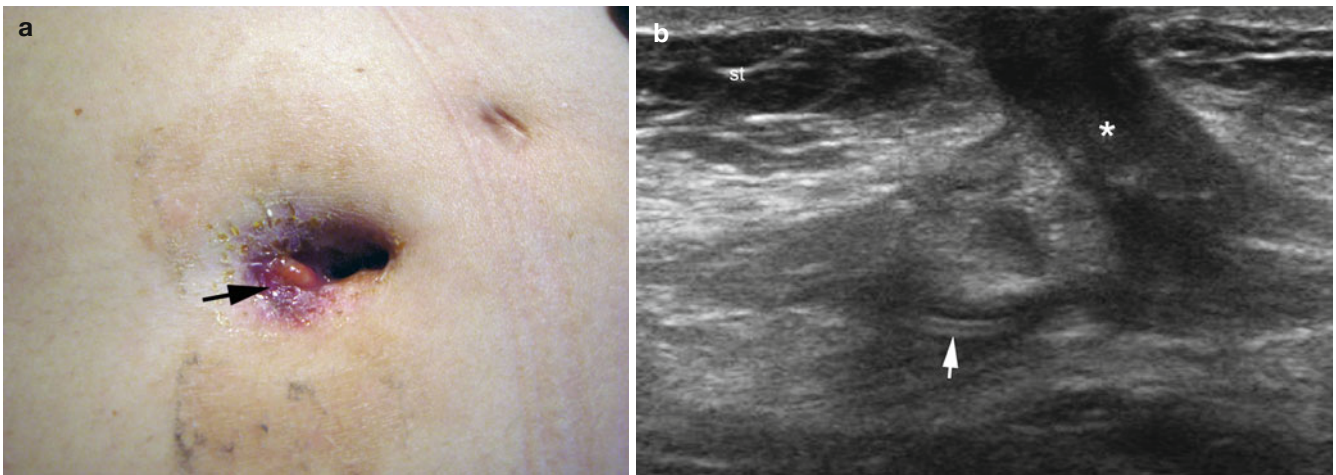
(a, b) Fluid collection, fistulous tract, and fragment of a catheter after abdominoplasty. (a) Clinical image of the umbilical region in a patient with a history of abdominoplasty demonstrates erythematous swelling (*arrow*). (b) Grey scale ultrasound image (transverse view, umbilical region) shows hypoechoic fluid collection that
